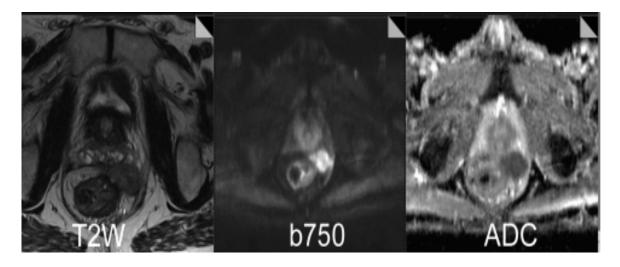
T2-weighted images show a well-defined lesion in the perirectal space. DWI was obtained at b = 750 and shows a high signal.
